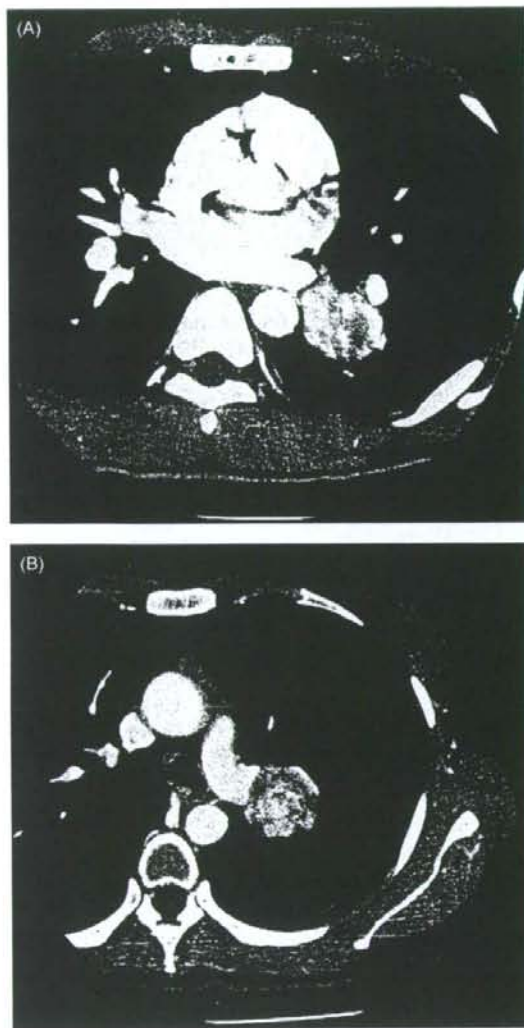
Mucoepidermoid carcinomas of the bronchus were well defined mass and had a smooth margin. Enhanced CT images shows marked heterogeneous enhancement with foci of relatively low attenuation (A, Case 1; B, Case 5).
